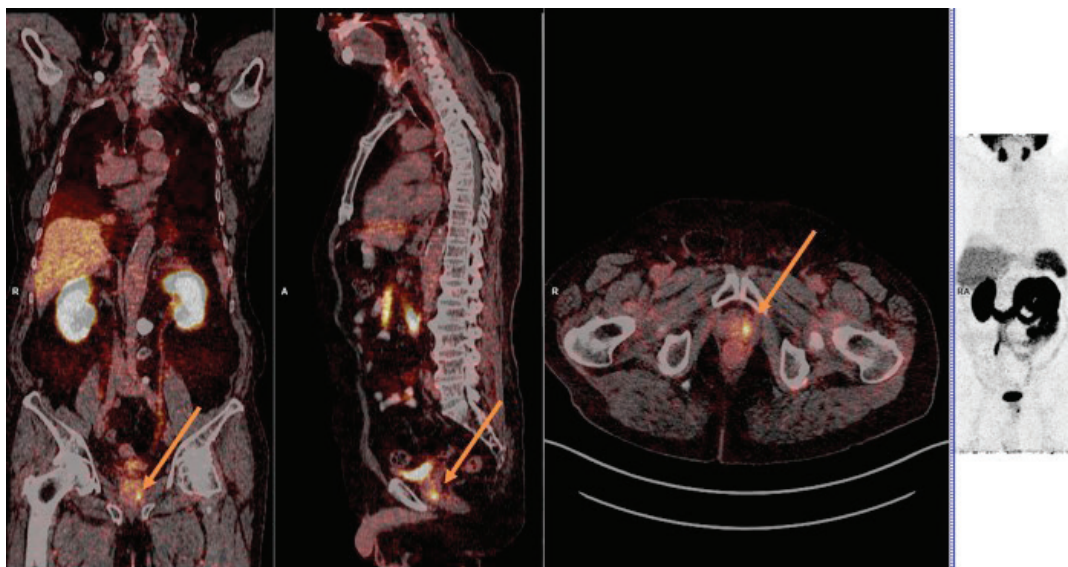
Local prostate recurrence in a patient treated with radiotherapy (PSA 2.30 ng/mL, PSA_{dt} less than 6 months). SUV_{max} 19.
